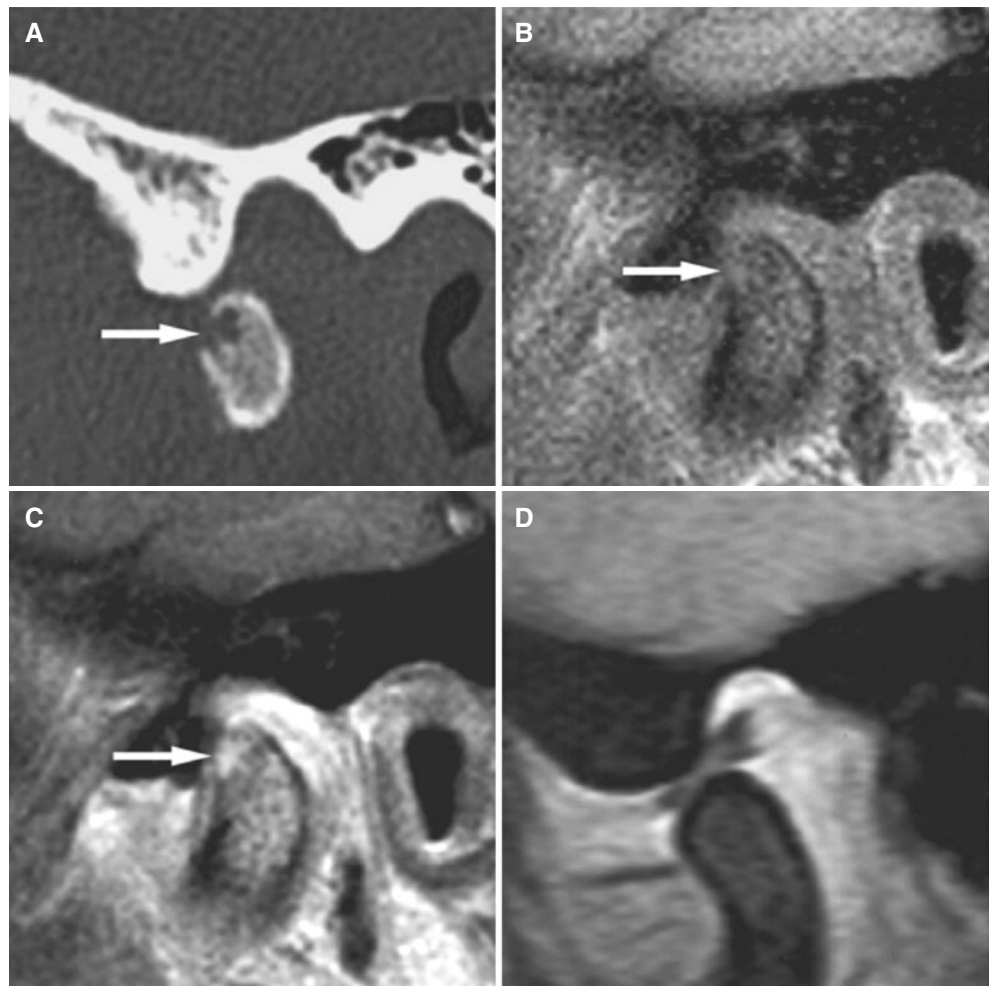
Psoriatic arthropathy (same patient as in Fig. 6.40). (A) Direct sagittal CT image shows punched-out erosion (*arrow*). (B) Oblique sagittal T1-weighted pre-Gd and (C) oblique sagittal T1-weighted post-Gd MRI show contrast enhancement within bone erosion (*arrow*) and in joint space, consistent with thickened synovium/pannus formation. (D) Oblique sagittal open-mouth MRI shows reduced condylar translation and normally located disc (bone normal in this section)
